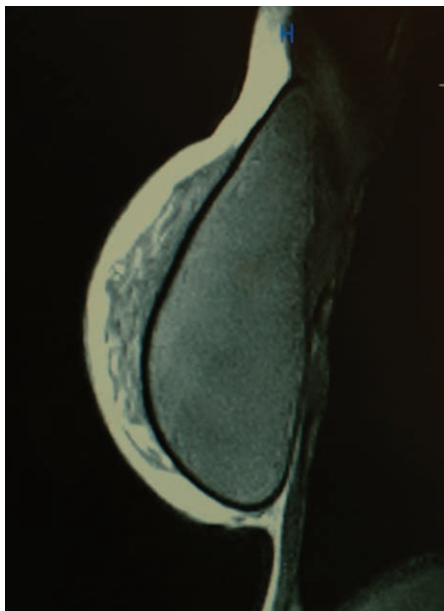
Upright magnetic resonance imaging scan of a MemoryShape implant.
